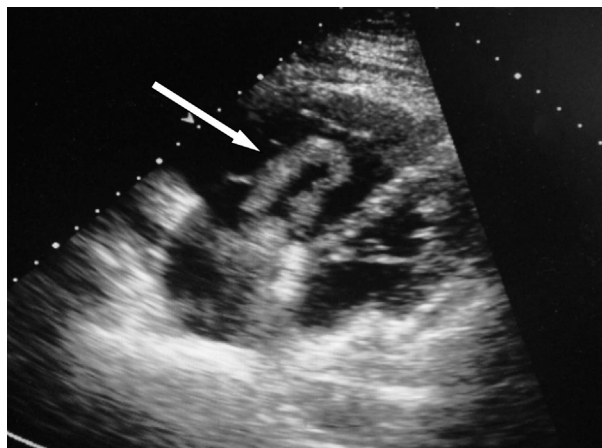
Bedside cardiac ultrasound showing a serpiginous, mobile mass in the right atrium representing a right heart thrombus in transit.
